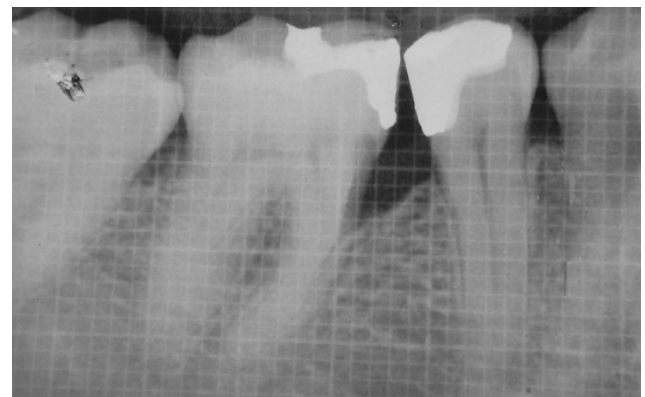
(e). X-Ray with Grid at baseline
